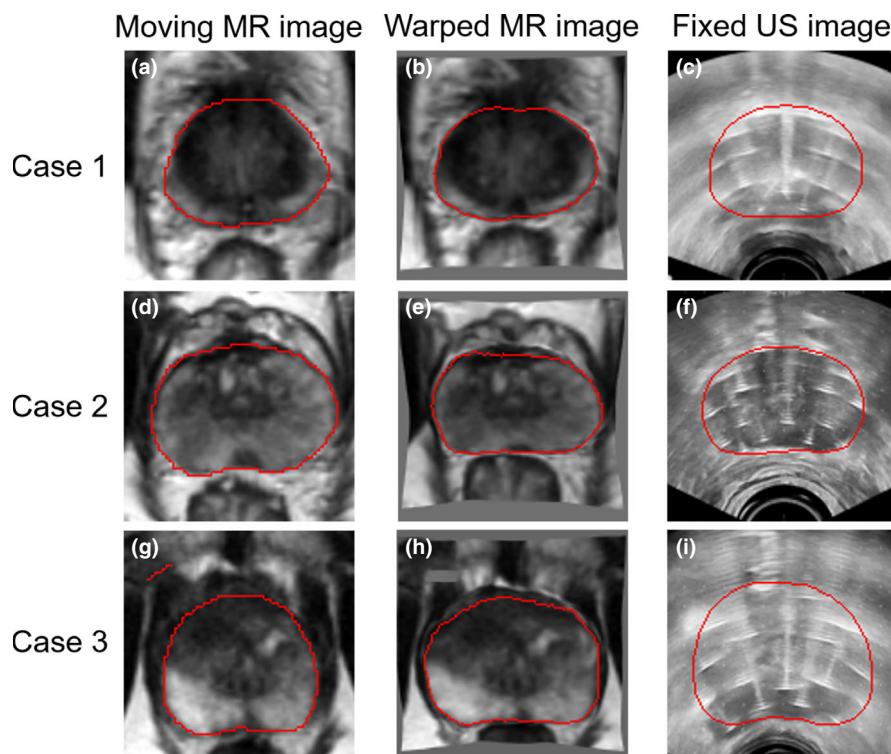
Comparison of the moving MR images (in the first column with manual contours), warped MR images after the deformable registration (in the second column with warped contours), and fixed US images (in the last column with manual contours) from three patient cases. All the three in-plane images of each patient case are corresponding to the same location in superior-inferior direction in the cropped image volume. The prostate contours are in red color. [Color figure can be viewed at wileyonlinelibrary.com]
